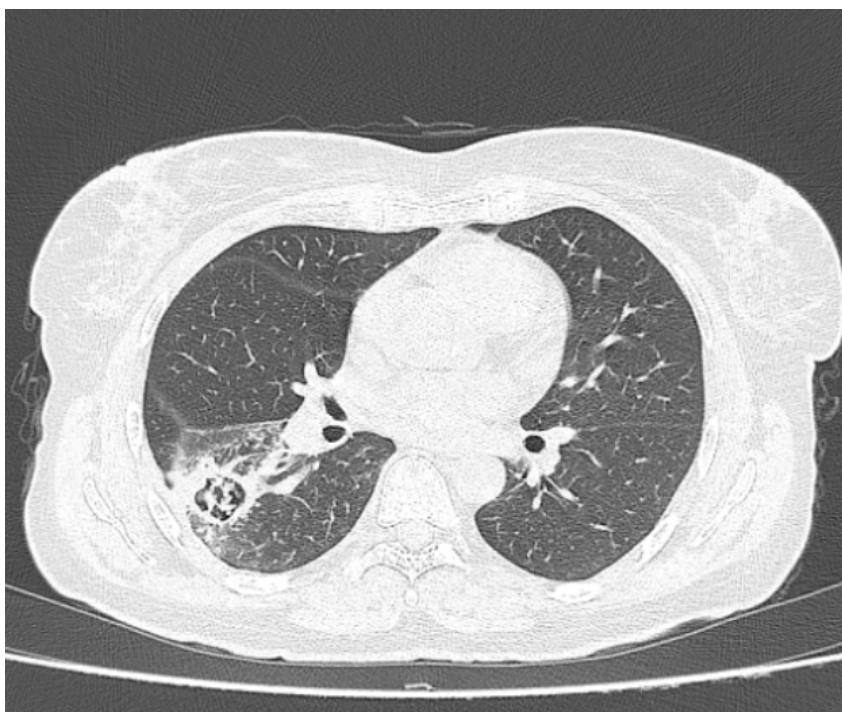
CT scan depicting the evolution of the cavitary lesion after exactly three months of systemic antibiotic therapy.
